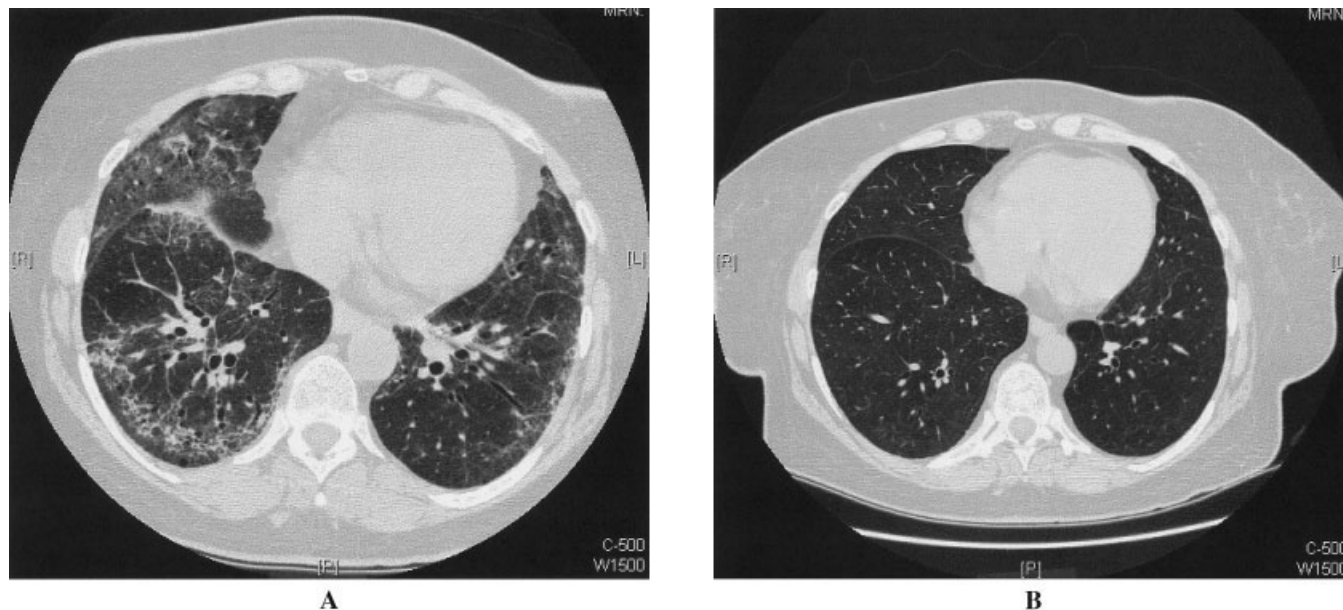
Chest high-resolution computed tomography image of patient 1 A, before, and B, after receiving mycophenolate mofetil.
